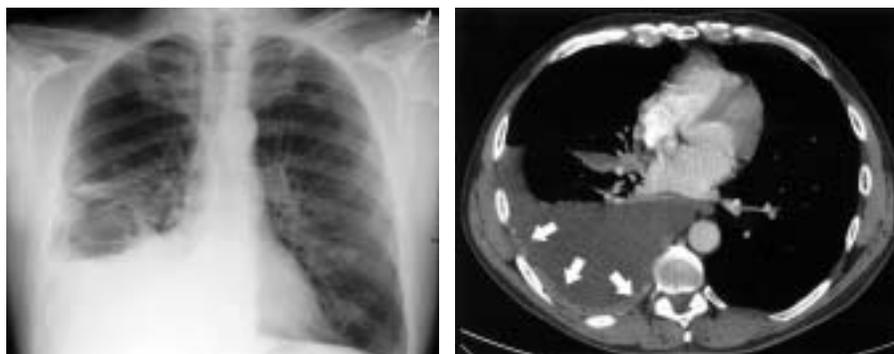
Left, Frontal chest radiograph of a 54-year-old man with a mass on the left kidney and dyspnea showing a moderate-sized right pleural effusion without unique diagnostic features of a malignant effusion. Right, Contrast-enhanced computed tomogram with mediastinal windows showing a right pleural effusion with irregular thickening of the parietal pleura (arrows). Computed tomography-guided pleural biopsy revealed metastatic renal cell carcinoma.
